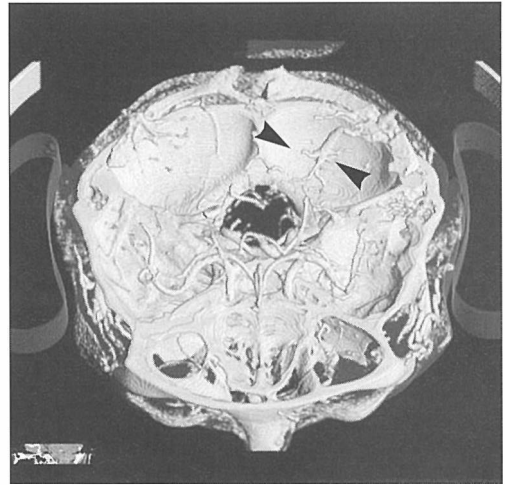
CT angiogram, volume rendering technique, anterosuperior view, shows venous angioma in left cerebellar hemisphere (arrows). The lesion has characteristic »caput medusa« configuration.
